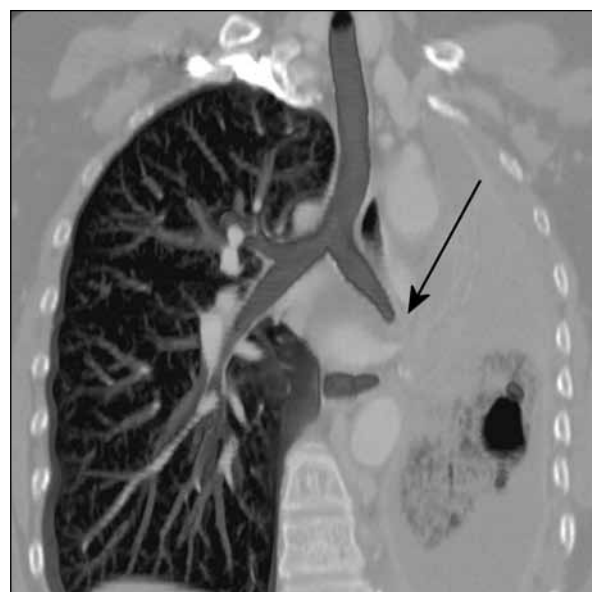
Coronal maximum-intensity projection computed tomographic image showing abrupt termination and complete obstruction of the left lower lobe bronchus at its origin (arrow)
